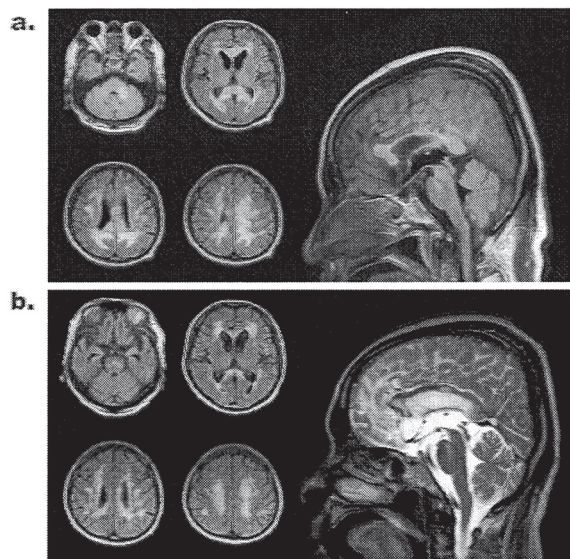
Axial and sagittal fluid attenuation inversion recovery (FLAIR) and T2-weighted sequences in brain MRI. a: At presentation: lesions are observed in the corpus callosum and in the left inferior cerebellar peduncle in addition to diffuse subcortical white matter abnormalities. b: After 4 months of treatment: the subcortical white matter hyperintense lesions became less remarkable, but the lesions in the genu and splenium of the corpus callosum persisted.
